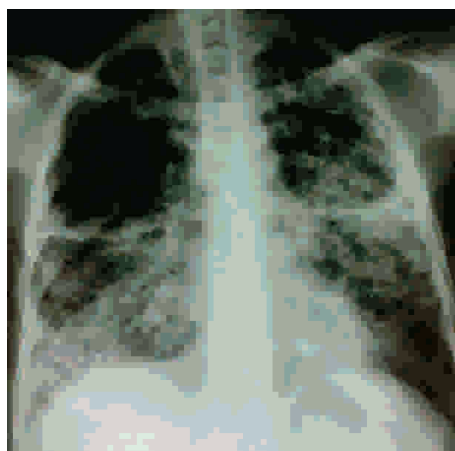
Chest X-ray, Extended and Bilateral Pulmonary Tuberculosis in a Woman
